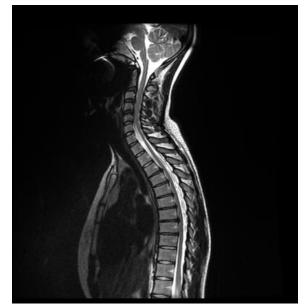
Spinal MRI: sagittal T2 section showing an anterior displacement of the spinal cord adhering to the vertebral body ranging from T4 to T8, erasing the anterior subarachnoid spaces and widening the posterior perimedullary spaces
